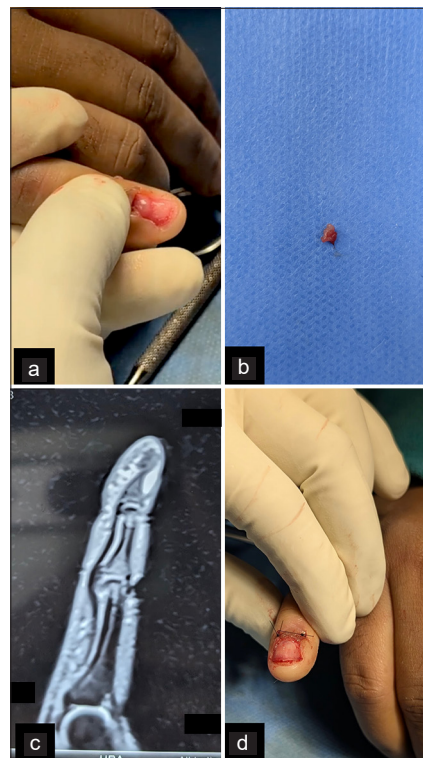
(a) Intraoperative image of the tumor over the proximal aspect of the nail bed after separation of nail plate from the nail bed. (b) Excised tumor following the procedure. (c) Magnetic resonance imaging of the subungual glomus tumor. (d) Post-operative image after suture-free fixation of nail plate using cyanoacrylate glue.
